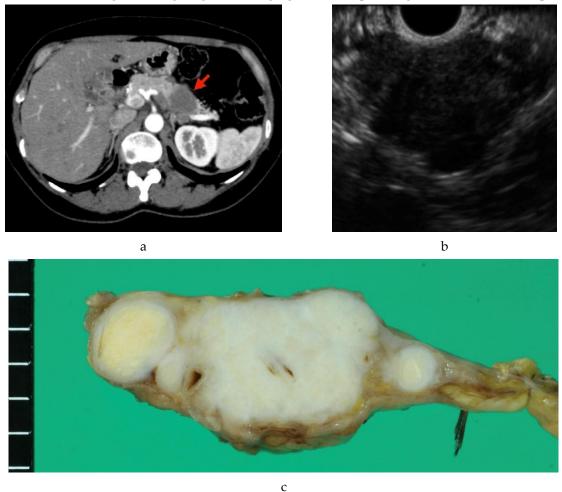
(a) Contrast-enhanced computed tomography (CT): an ill-defined mass (arrow) with a hypovascular enhancement pattern. The dilated pancreatic duct is notable. (b) Endoscopic ultrasound
